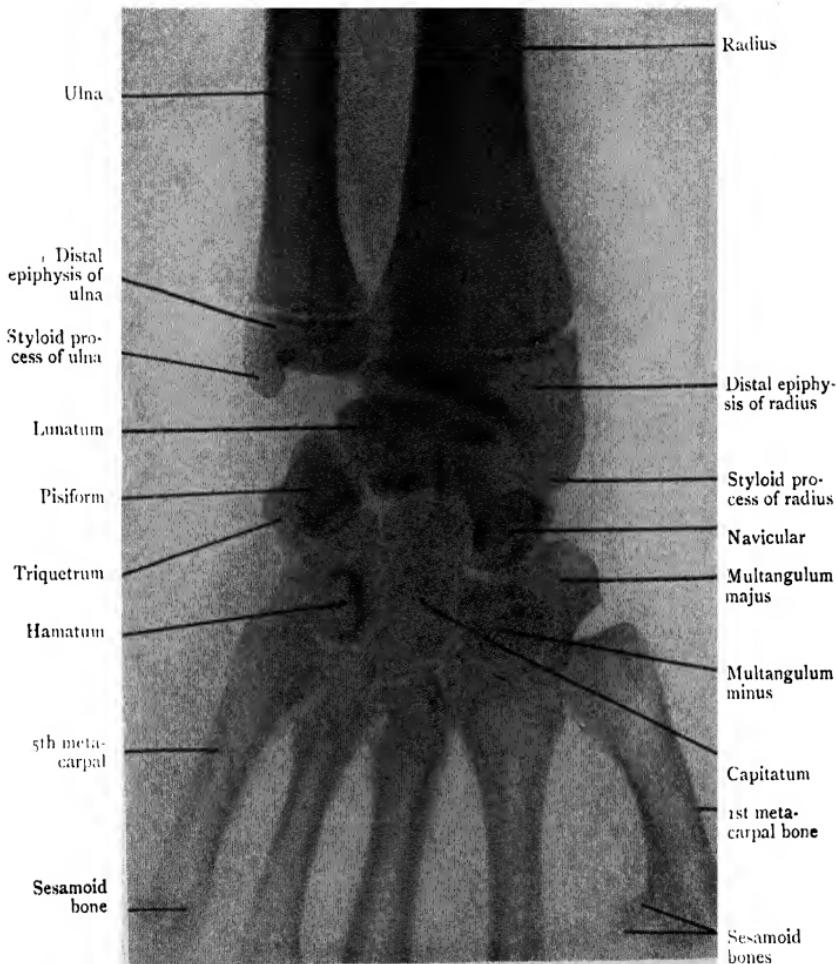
Antero-posterior Radiograph of the Wrist of a Person of 19 years.
